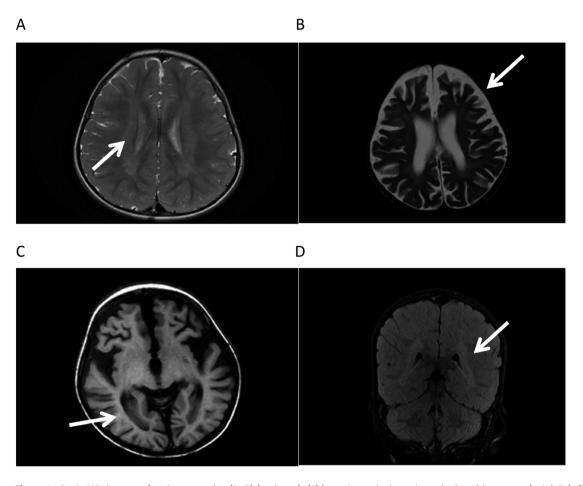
Brain MRI images of patients 1 and 2. (A-B) (patient 1): (A) hyperintensity in periventricular white matter (axial, T2), (B) diffuse brain atrophy, more prominent in the frontotemporal (axial, T1), (C-D) (patient 2): (C) hyperintensity in periventricular white matter (axial, T2), (D) hyperintensity in periventricular white matter (coronal flair).
